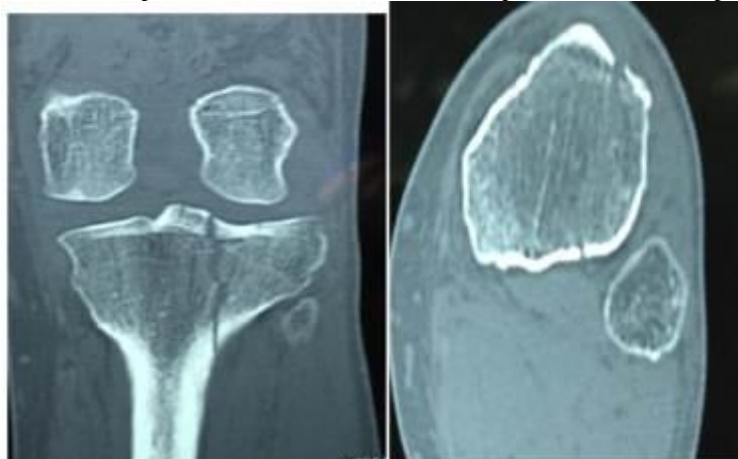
axial and coronal views of split fracture tibial plateau (CT scan)
